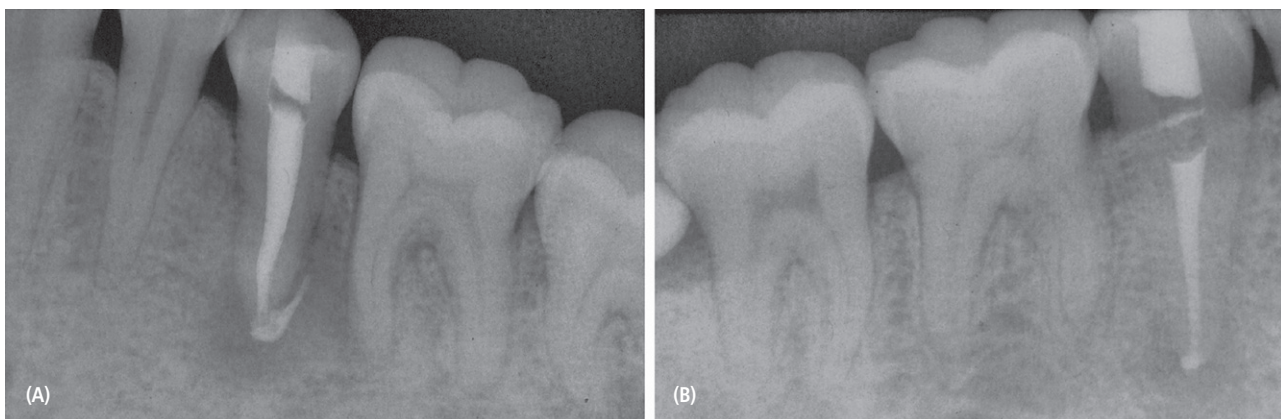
PA radiograph of teeth 20 (A) and 29 (B) taken immediately post root canal treatment.
